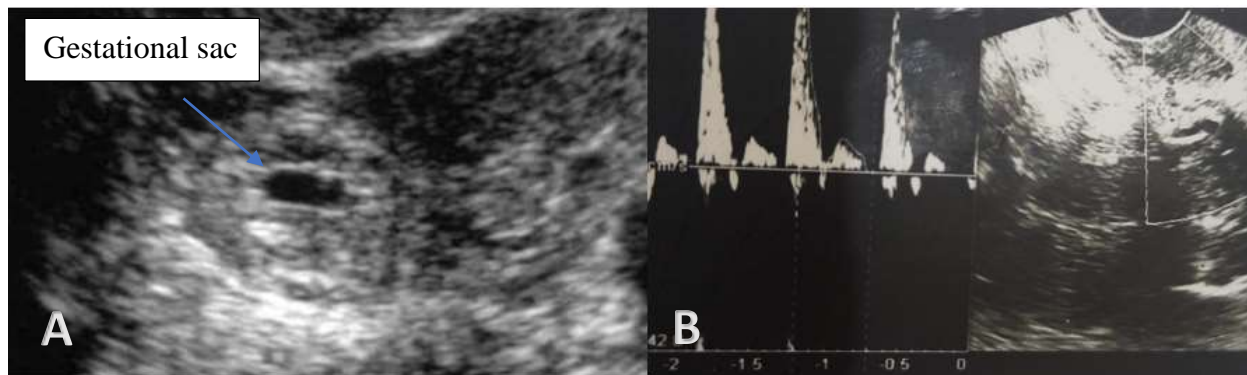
Left tubal pregnancy at 6 weeks of gestation. A 36 years old female presented with pelvic pain, vaginal bleeding, and 45 days of amenorrhea and was positive for the urine pregnancy test. (a) The Grey scale image shows normal size uterus with normal endometrium. A gestational sac is seen in the left fallopian tube with no embryonic pole. (Appointed by an arrow) (b) Transvaginal Doppler image shows the left uterine artery spectrum obtained by power Doppler shows the indices RI= 0.78 and PI=2.72.
